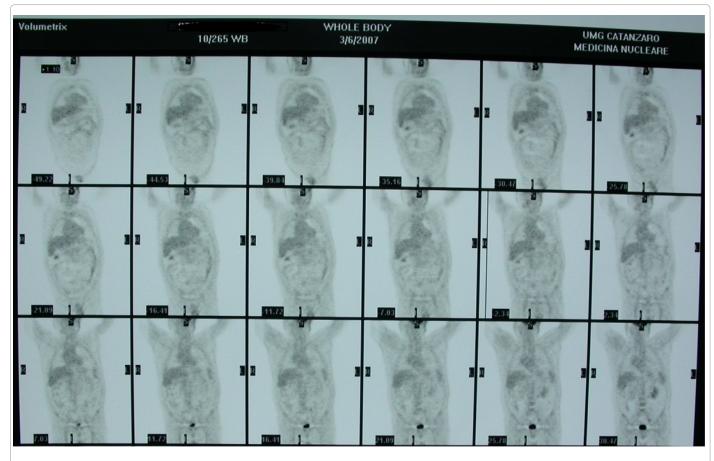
Total body scintigraphy after 12 months since surgery.
